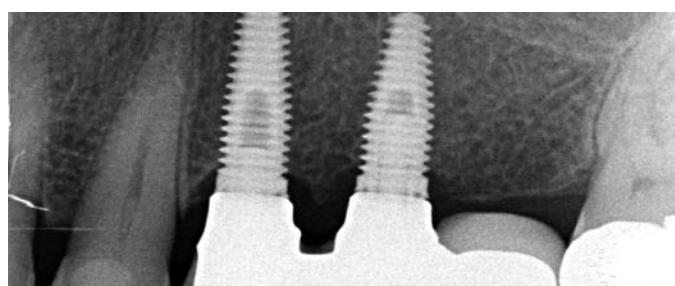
Control radiograph of the final situation.
